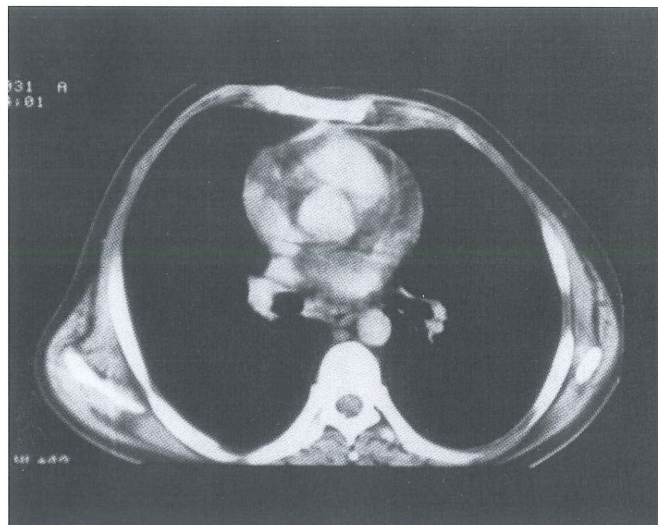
Normal thorax computed tomography obtained one year after admission
